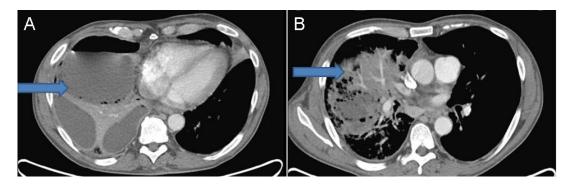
Thoracic CT scan showing right-sided necrotizing pneumonia, lung abscess and empyema (arrows).
